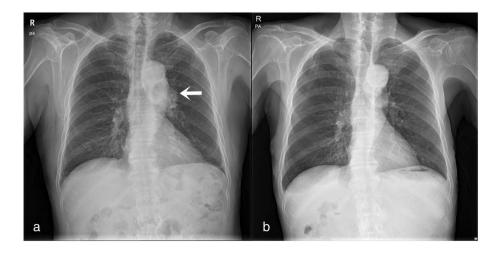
(a) Chest X-ray shows a bulging contoured lesion in the left hilum and (b) chest X-ray shows the previous bulging contoured lesion has completely disappeared in the left hilum
